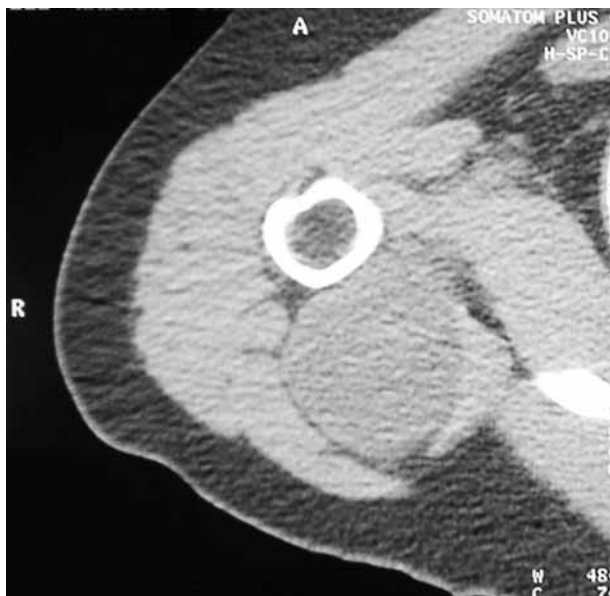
CT examination of the shoulder revealing a 6 × 4 × 6 cm mass containing both solid and cystic components, with the solid components showing heterogeneous enhancement.
